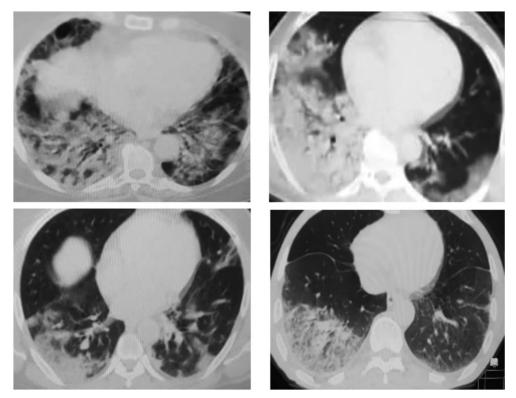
42 male patient complainting of fever and expecturation, Axial CT chest parenchymal window, different images of lung consolidation seen as in homogeneous opacity with air bronchogram inside.
